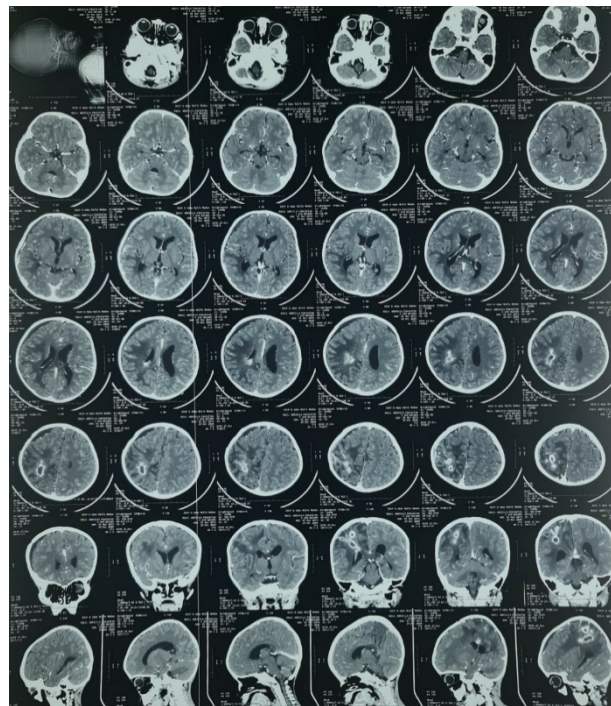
Head Contrast CT scan after giving Intravenous Antibiotic for one month
